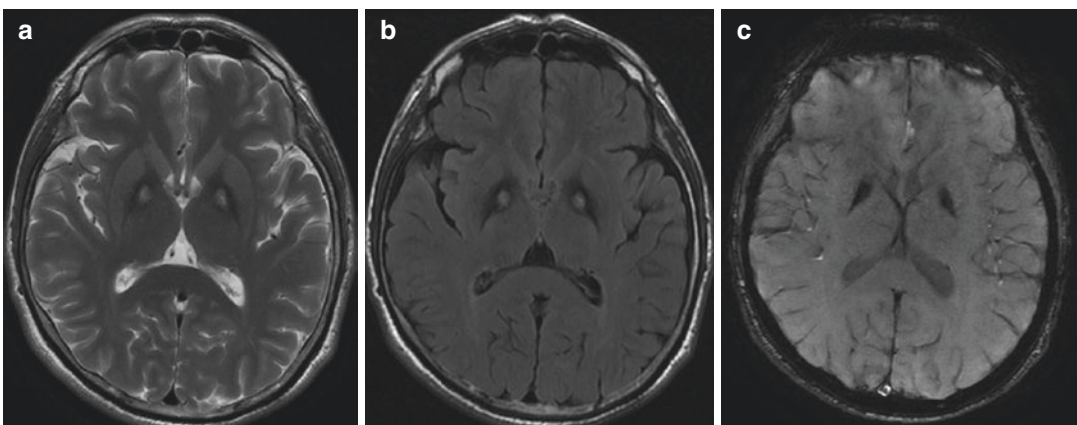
Brain MRI of the patient revealed bilateral hyperintensity within surrounding hypointensity in the globus pallidus on T2 weighted (a) and T2-FLAIR (b).
